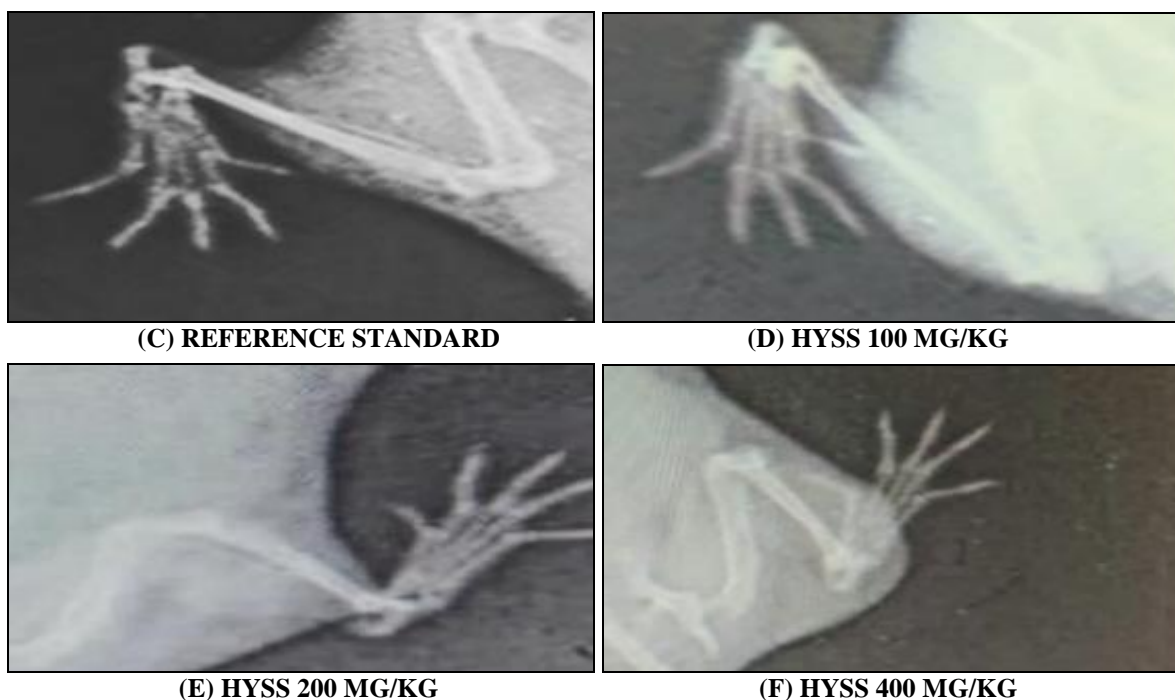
RESULT OF RADIOGRAPHIC ANALYSIS
